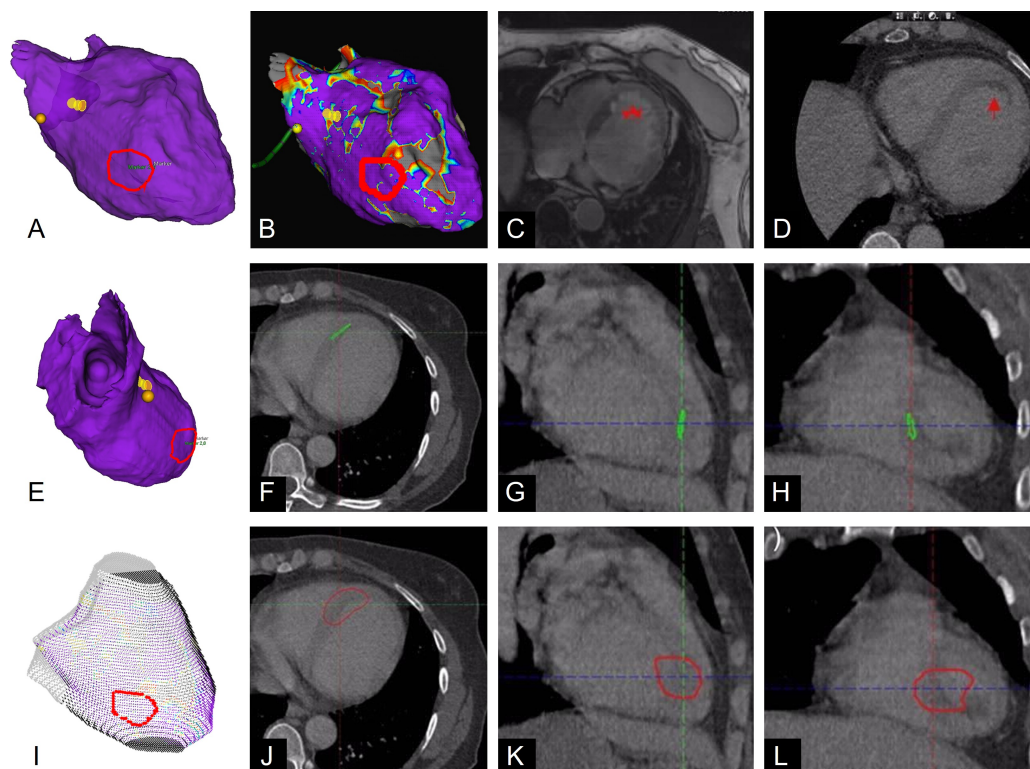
Case 2. (A, B, E) Electroanatomical mapping data with the ventricular tachycardia (VT) target region (red) in anterior-posterior and left lateral views from EnSite NavX system. (C) Pre-stereotactic arrhythmia radioablation contrast-enhanced cardiac computed tomography (CT) in systolic phase. Red arrow: septal-apical hypoattenuation indicating fibrosis/scarring. (D) 3.0 Tesla cardiac magnetic resonance imaging, transaxial navigated 3D fast low angle shot magnetic resonance imaging sequence with inversion recovery showing pronounced late gadolinium enhancement indicating cardiac fibrosis/scarring. (F-H) Axial, sagittal and coronal views of the cardiac CT with 2D-3D registered VT target (green). (I) 3D view of the left ventricle point cloud and the 2D-3D registered VT target points (red). (J-L) Axial, sagittal and coronal views of the planning CT with the final cardiac clinical target volume (red).
